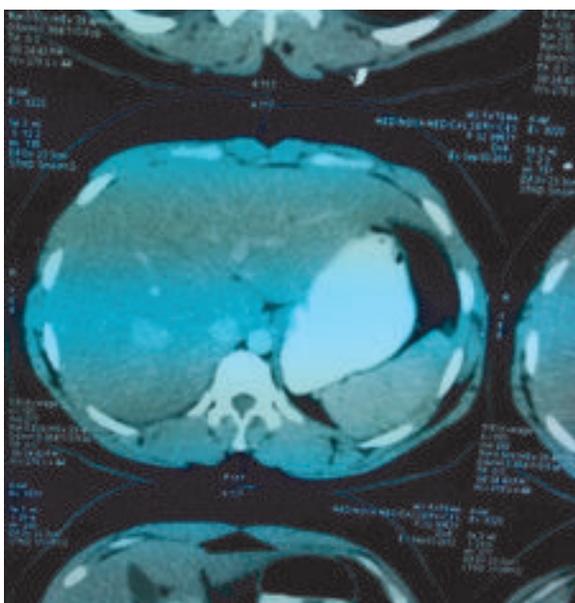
CT scan of upper abdomen showing enhancing isodense lesion in right lobe of liver.
